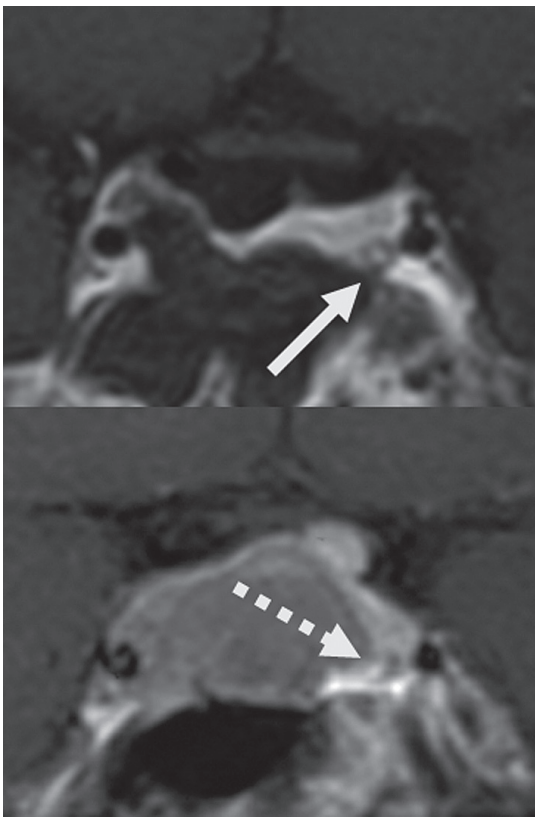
MRI, obtained after the 1st operation, confirmed the total removal of the macroadenoma, and suggested the presence of a microadenoma (arrow) in the compressed normal gland, which was also recognized on preoperative MRI (dot arrow).
